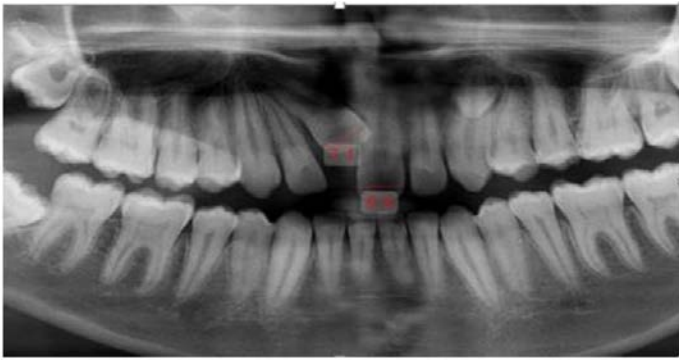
Panoramic radiograph showing magnification index
